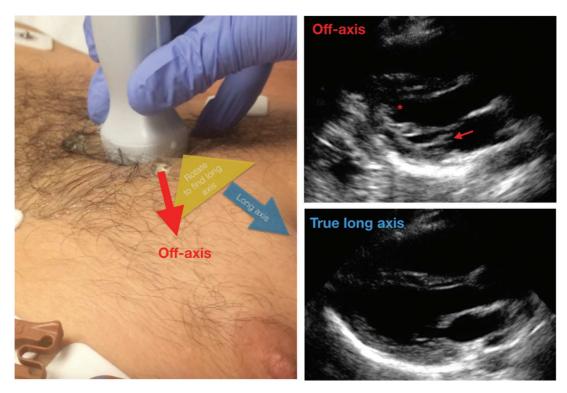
Rotating scan plane to find the true parasternal long axis. Note that in this patient, with the indicator pointed inferior to the nipple, the plane is off-axis. This is apparent as the left ventricle (LV) chamber appears rounded (*), and there is abundant papillary and chordal tissue seen (arrow). By slowing rotating the probe in either clockwise or counterclockwise direction, the image on the screen will either show the LV elongating or progressing to a short axis view. By rotating in the direction of LV elongation, a true long axis is obtained.
